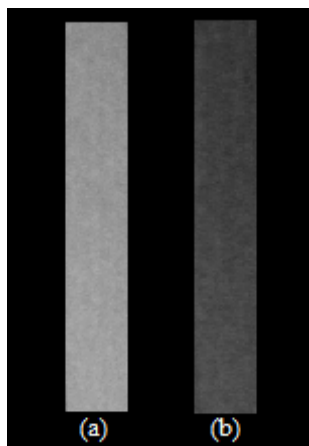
X-ray of the radiochromic film layers, white base (a) transparent coating (b).
